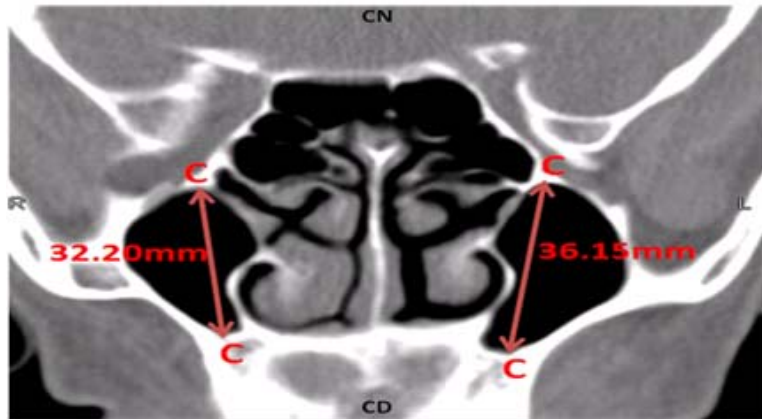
Coronal CT of a 30 year Old Female Showing Measurements of the Craniocaudal (Height) Diameter CC. The Right CC was 32.20mm while the Left CC was 36.15mm. R= Right side, L= Left side, CN= Cranial end, CD= Caudal end.
